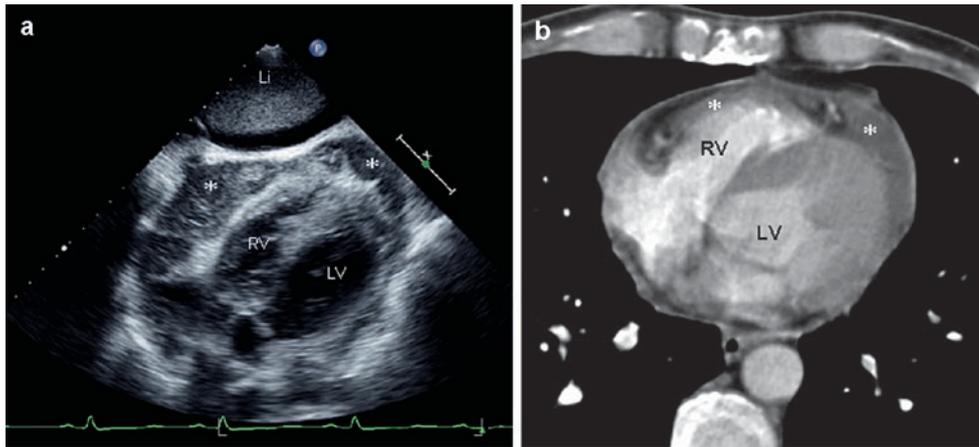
Secondary cardiac manifestation of thymus carcinoma in a 52-year-old male patient with infiltrative pericardial and myocardial growth. Trans-thoracic echocardiographic image from a sub-costal view (a) shows the tumour (asterisks) hypo-dense relative to the myocardium and with heterogeneous appearance. (b) Cardiac
